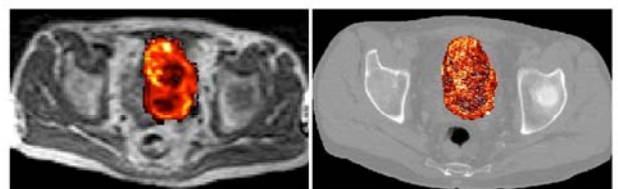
Example MR and CT K^{trans} maps (scale:0-0.5) transformed to CT space
